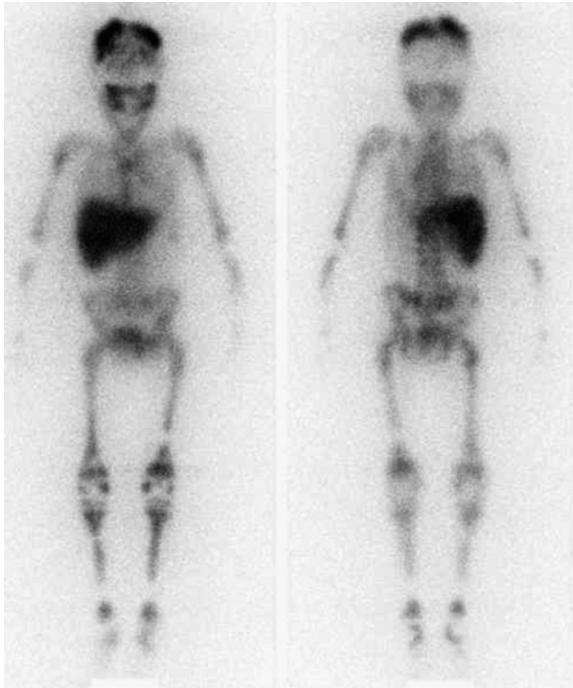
Four-year-old patient with neuroblastoma stage 4. Whole body MIBG scintigraphy shows the images at diagnosis (a) with the abdominal primary tumor, hepatic metastases and skeletal infiltration in the skull, and the upper and lower limbs. The follow-up examination (b) reveals a complete response after chemotherapy and operation
